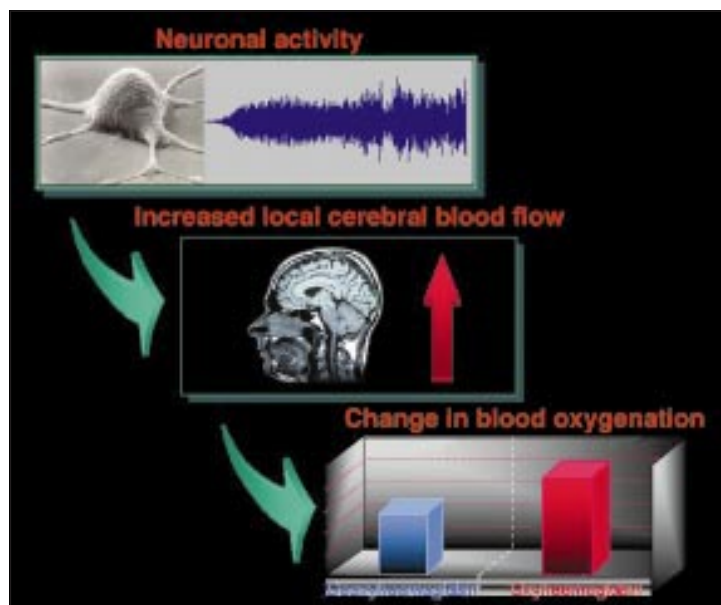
Principles involved in converting neuronal activity into a blood oxygenation level dependent (BOLD) signal, which can be measured with functional magnetic resonance imaging
